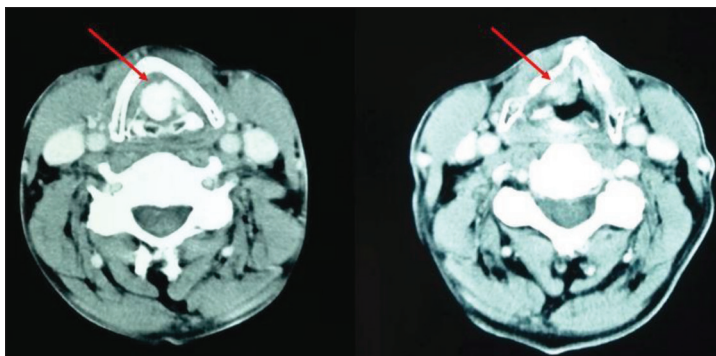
Computed tomography scan of the neck: axial views; arrows point to laryngeal osteosarcoma
